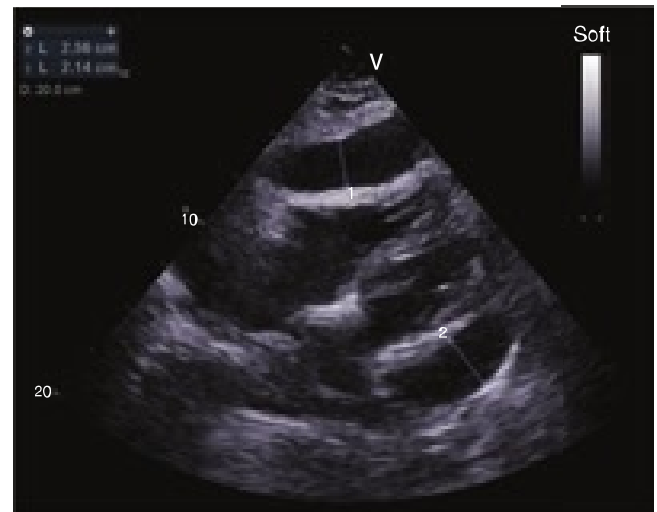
Subcostal four-chamber view on transthoracic echocardiography demonstrating a large pericardial effusion (measuring ≥ 20 mm in diastole).
